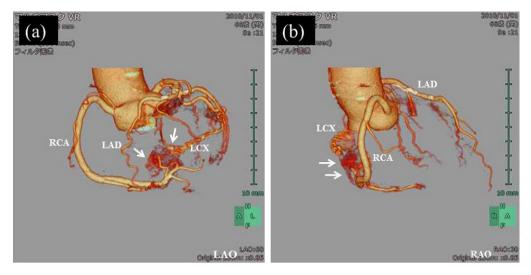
Computed tomography images reconstructed by the volume rendering technique in the left anterior oblique (LAO) view (a) and the right anterior oblique (RAO) view (b). Coronary arteriovenous fistulas (arrows) arising from the distal right coronary artery (atrioventricular nodal branch) and from the tortuous distal circumflex coronary artery that drain into the right atrium can be seen. RCA, right coronary artery; LCX, left circumflex artery; LAD, left anterior descending coronary artery.
